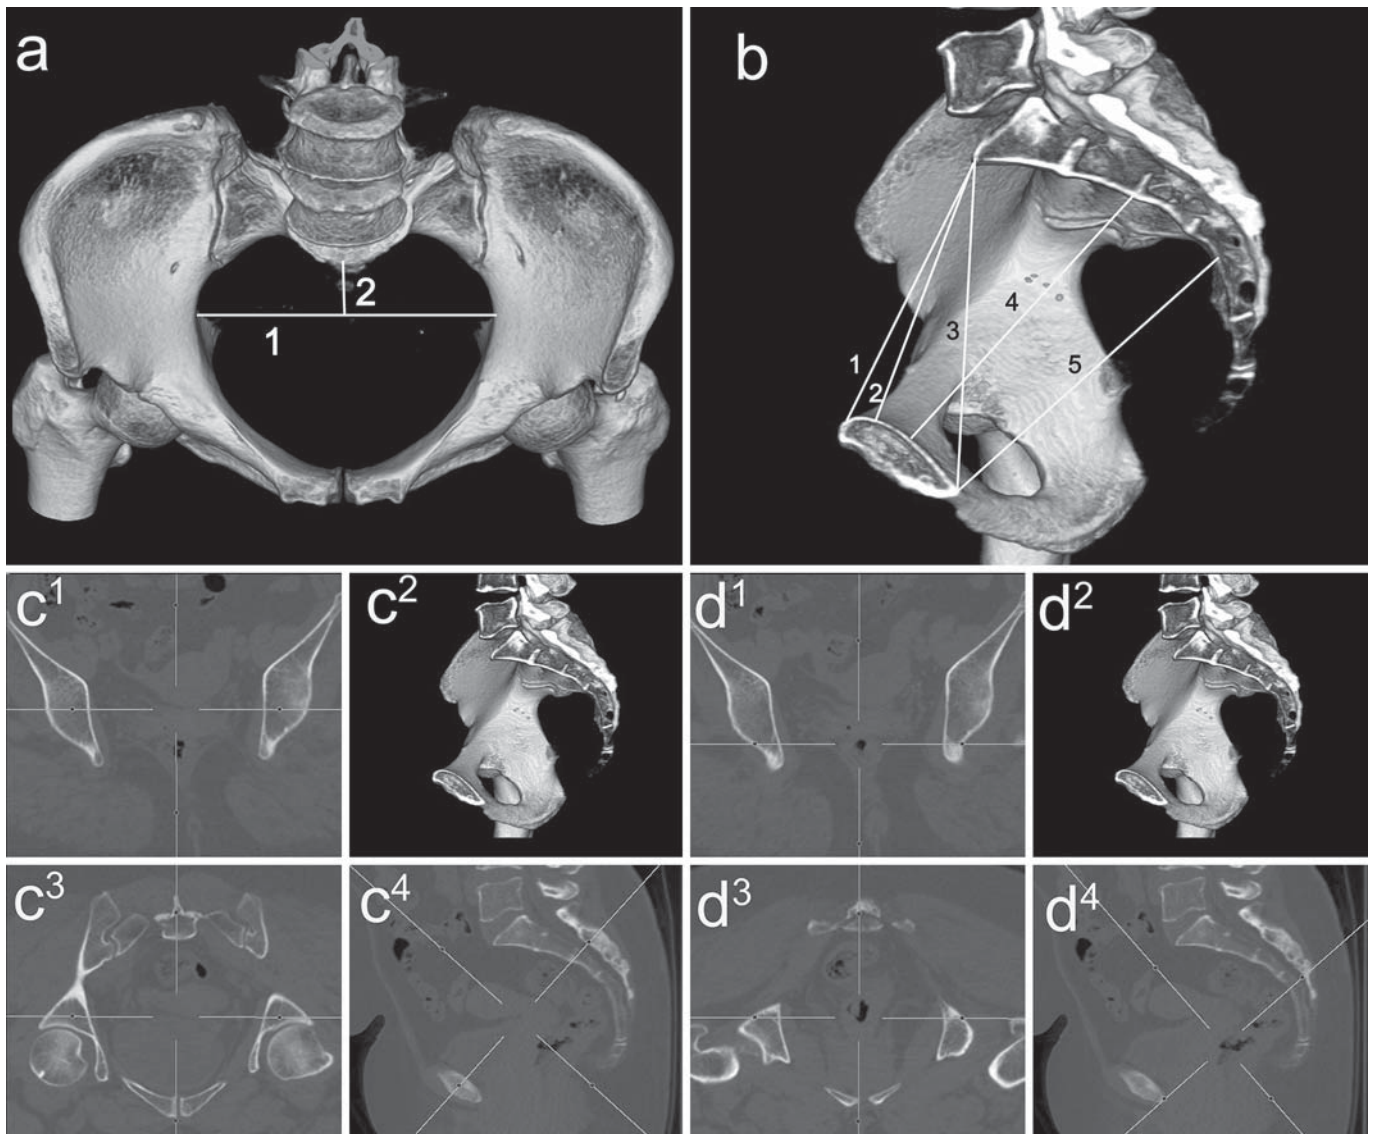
Representative 3D and reformatted CT images of gynecoid pelvis (37-year-old woman, parity: 4). a Measurements of transverse (1; 140.1 mm) and posterior sagittal (2; 49.4 mm) diameters of the pelvic inlet. b Measurements of true (1; 118.6 mm), obstetric
